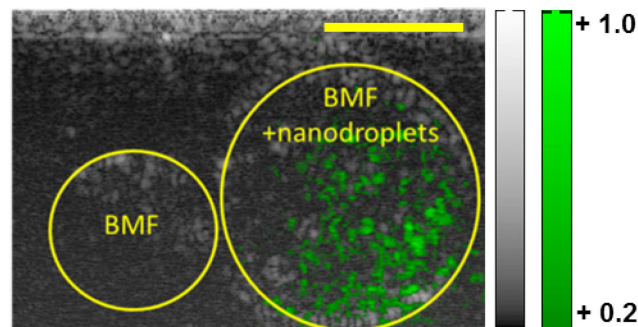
Flash-difference images of nanodroplets in between a latex membrane. The latex membranes were filled with blood-mimicking fluid (BMF) with (right) or without (left) nanodroplets. Yellow scalebar represents 5 mm. The gray and green colormap represents ultrasound signal before the HIFU pulse and the percent change in ultrasound signal after the HIFU burst, respectively [35].
